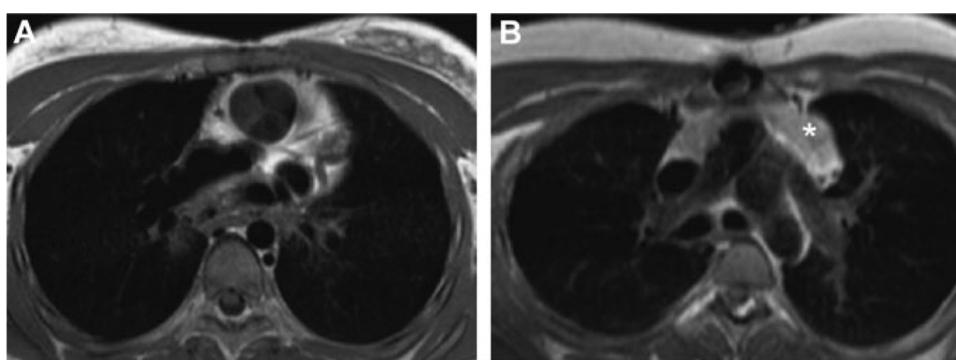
Visualisation of thymic tissue in thymectomized individuals. (A) MRI of a patient (T25) 10.6 years post-thymectomy with no evidence of thymic tissue. (B) MRI of a patient (T30) 16.5 years after neonatal thymectomy showing thymic tissue (*).
